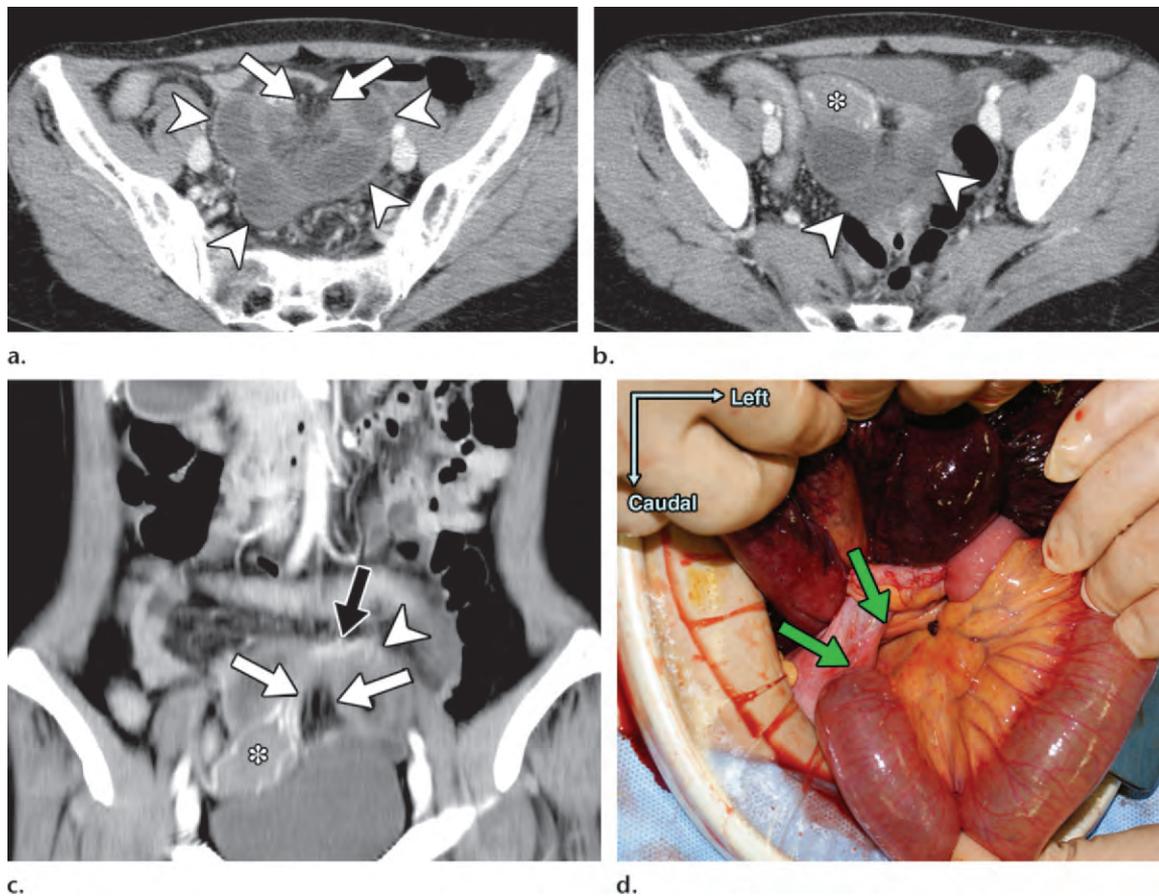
Broad ligament hernia in a 58-year-old woman with a 1-day history of intermittent abdominal pain and vomiting and a history of three normal pregnancies. (a, b) Axial contrast-enhanced CT images obtained at different levels show a cluster of small bowel loops in the pouch of Douglas (arrowheads) and crowding mesenteric vessels (arrows). The uterus (*) is deviated inferiorly and to the right. (c) Coronal MPR CT image shows the hernia orifice (white arrows) below the tubal and ovarian branches (black arrow) of the left ovarian and uterine vessels. Enlargement of the distance between the uterus (*) and the left ovary (arrowhead) is also seen. The patient's abdominal pain acutely intensified, and open surgery was performed. (d) Intraoperative photograph (anterior view) shows incarceration of the small intestine through a thumb-tip-sized defect (arrows) in the left broad ligament of the uterus. Approximately 70 cm of incarcerated intestine was infarcted and was resected, and the broad ligament was sectioned. (Fig 18a and 18d adapted and reprinted, with permission, from reference 68. Fig 18b and 18c courtesy of Yukio Nishiguchi, MD, Osaka City General Hospital, Osaka, Japan, and Tetsuro Ikeya, MD, Osaka City University Graduate School of Medicine, Osaka, Japan.)
